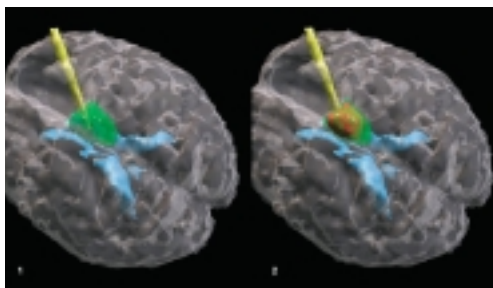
Using a computer-assisted MRI three-dimensional reconstruction of a patient's brain, a tumor (green) has been identified which can then be characterized by taking a biopsy (first panel). This same approach can be utilized to kill the tumor with heat by using a laser fiber (second panel). This innovative MRI-assisted technique illuminates heated tissue (in red), guiding the surgeons so that they can avoid killing normal tissue. The blue regions are the ventricles of the brain. This figure provided courtesy of Dr. Ferenc Jolesz, Brigham & Women's Hospital, MA.
